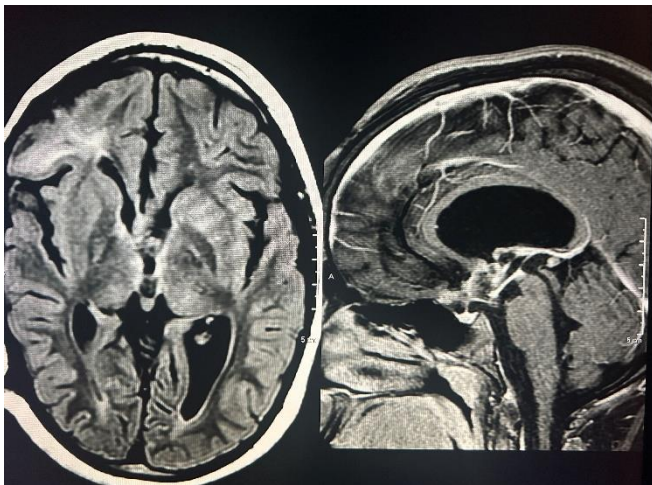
Magnetic resonance imaging of the brain (on contrast-enhanced T1-weighted axial Flair and sagittal sequences) (GE 1.5 Tesla) showing a significant reduction in areas with previously identified signal changes, in addition to the reduction in the volume of the solid-cystic lesion after the use of bleomycin via Ommaya reservoir.
